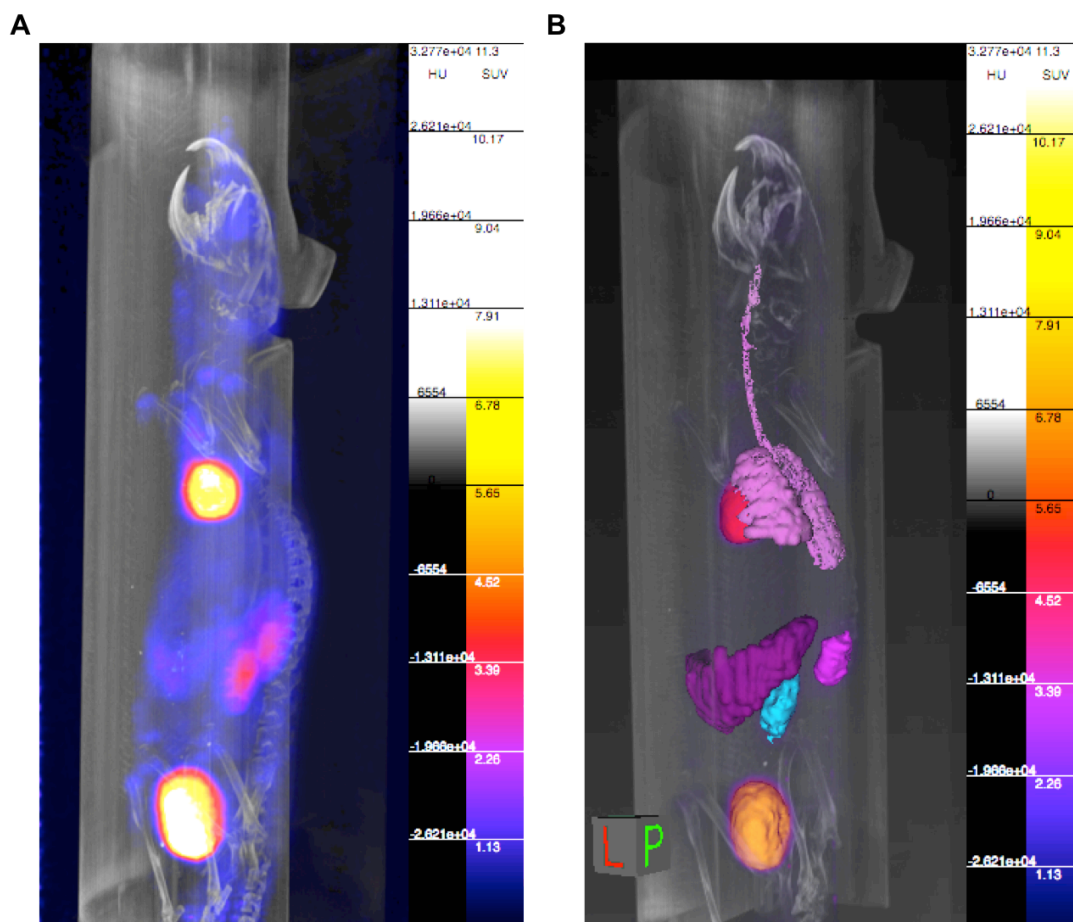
VivoQuant software can create 3D renderings of PET/CT data and ROI positions. (A) Shows a 3D Maximum Intensity Projection (MIP) image of the PET/CT image shown in Figure 3.15. (B) Shows the 3D rendering of the ROIs drawn in Figure 3.5 on a MIP image.
